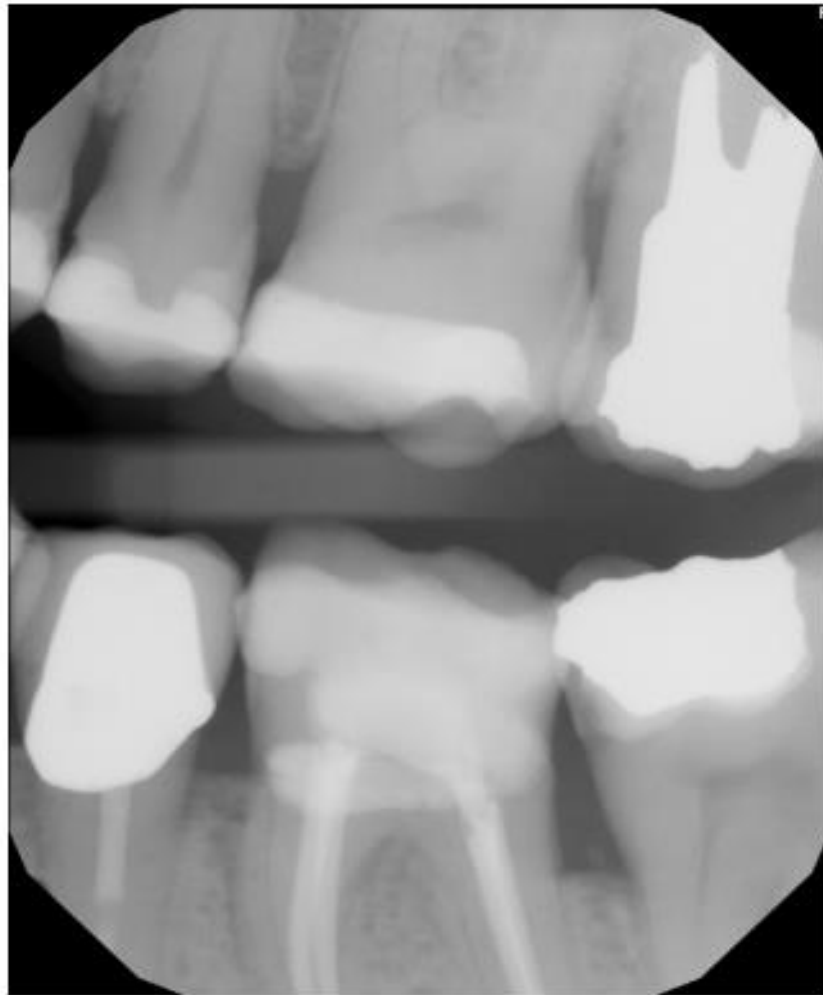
Stage 2 Periodontal Disease (mandibular + maxillary left posterior) bitewing radiograph: Radiographic bone loss limited to the coronal third (15%–33%). Image provided by authors.
